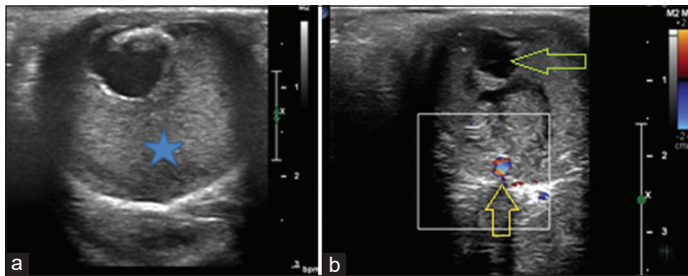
Ultrasonography images. (a) Gray scale image with high-frequency linear probe shows vitreous humor as echogenic region with coarse echoes suggestive of vitreous hemorrhage (star). (b) Custom factory integration image shows echolucent area next to lens (green arrow) and the normal vessels seen at the entry of optic nerve (yellow arrow)
